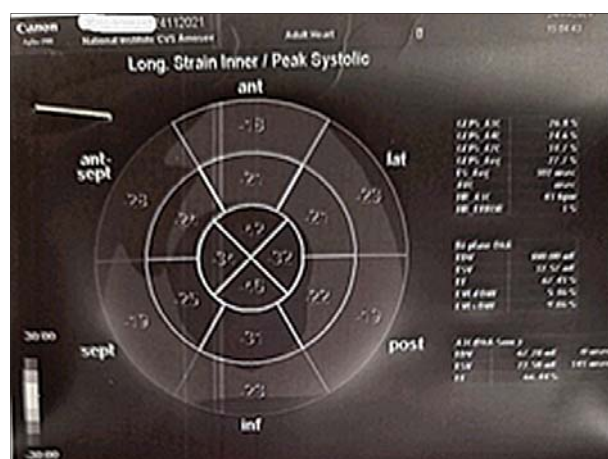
Stress echocardiography during restitution period (after LMCA stent placement)
